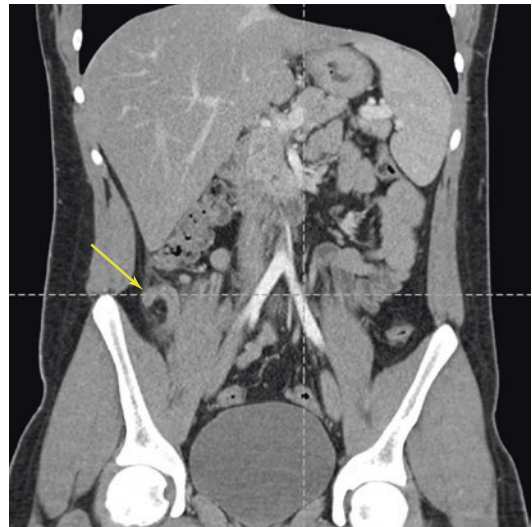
Retro-cecal sub-hepatic appendicitis (yellow arrow) on coronal reformatted CE-CT in a 16-year-old-boy
